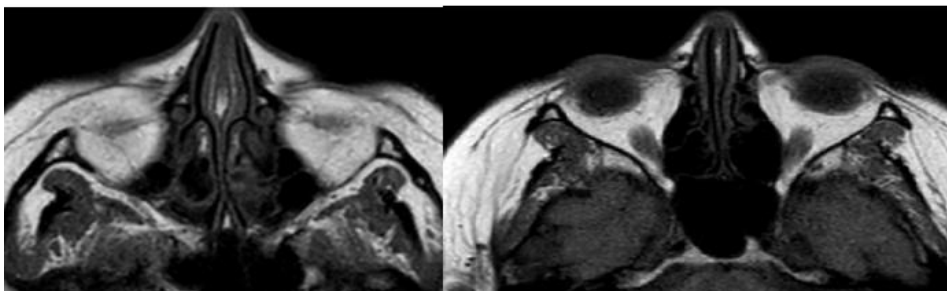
MRI revealing the borders of the previously observed infraorbital lesions on the right side were indistinguishable.
